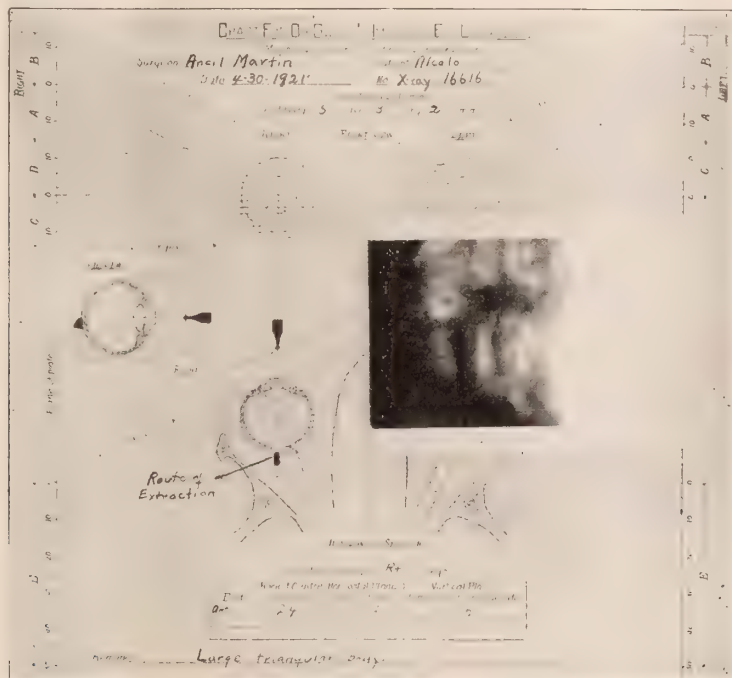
O. A., injured April 28, 1921. Large central corneal wound in right eye, with swollen and flocculent lens; pupil irregular in size; tension minus. X-ray showed a large foreign body, 5x2x3 mm. in size, located just posterior to the globe, in the vertical plane, and just below the horizontal plane, having the density of heavy metal. Wound of exit evidently between macular region and nerve disc and may have injured both. Through a canthotomy opening into orbit on temporal side, foreign body was extracted with magnet. Patient discharged May 17 with eye quiet, tension normal, traumatic cataract. Light perception present. Comment.—Accurate localization of this foreign body permitted its removal without further injury to the eye.
